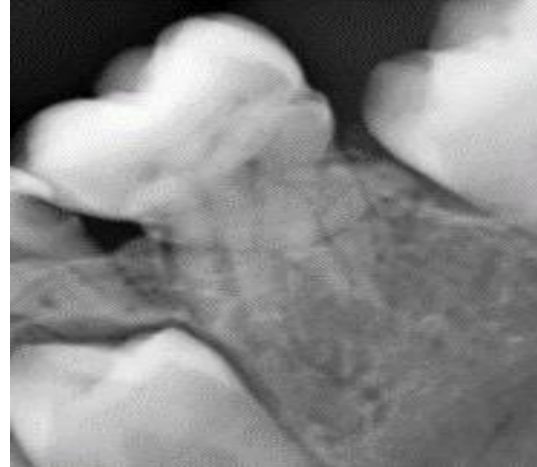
Periapical X-ray of tooth number 36.
